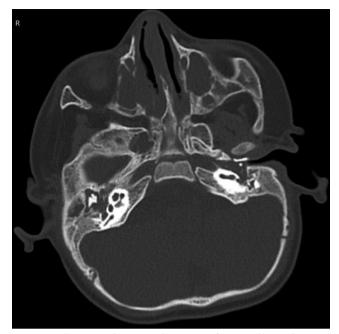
Axial computed tomography section of temporal bone shows, right aural atresia, and fullness and haziness in the middle ear.
